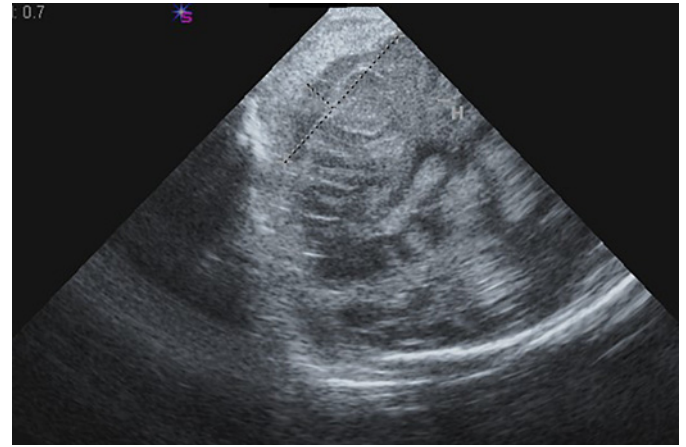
First brain ultrasound: brain ultrasound on day 1 of life showing crescent shape hypoechoic collection in the left frontoparietal region measuring 5×0.7 cm suggestive of SDH with overlying echogenic area probably denoting layering of the hematoma. An echogenic focus was seen in the falx measuring 1.7×0.8 cm which could be clotted blood. No midline shift or ventricular dilatation was noted.
